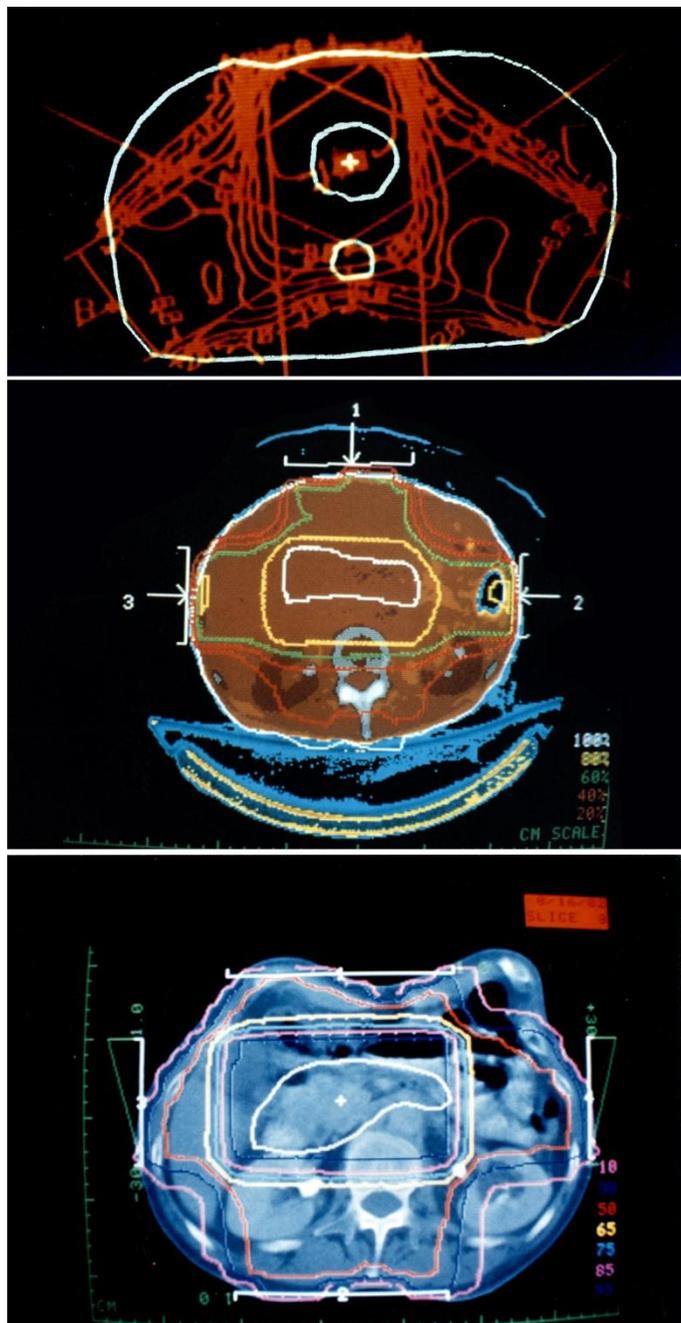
Three iterations of computer-assisted radiation therapy planning developed at LLUMC. Top (1971-72): image from ultrasound-based radiotherapy planning system. Middle (1975-76): image from CT scan-based planning system. Bottom (1986): image from refinement of CT-scan-based system. CT scans enabled inclusion of tissue-density data into the planning process.
